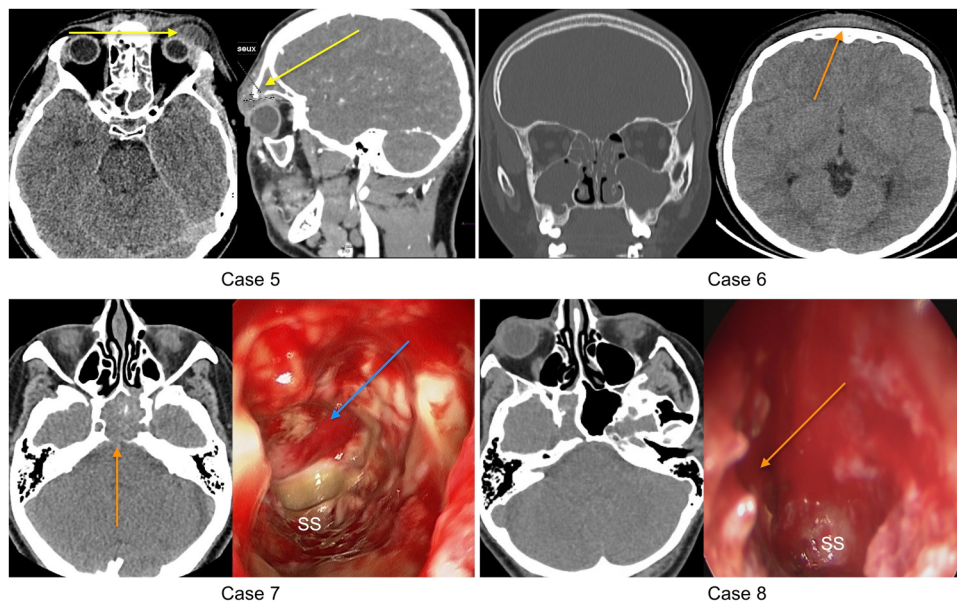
Case 5: axial and sagittal CT show left side supra orbital and frontal sub-periosteal abscess. Case 6: coronal CT shows bilateral pansinusitis. Axial CT shows frontal sub-periosteal abscess. Case 7: axial CT shows left side sphenoid sinusitis and bony erosion on the posterior wall. Intraoperative endoscopic view shows area of extensive bony erosion on the posterior wall of the sphenoid sinus. Case 8: axial CT shows right side sphenoid sinusitis and bony erosion on the lateral wall. Intraoperative endoscopic view shows area of large bony erosion on the lateral wall of the sphenoid sinus.
